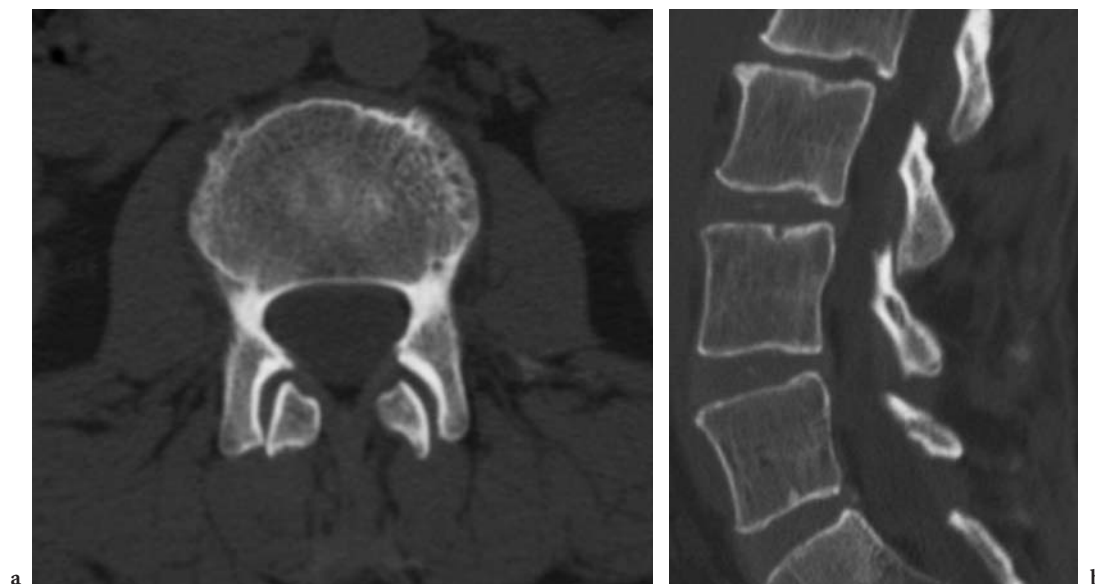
Facet joint subchondral bone changes. Axial CT image at the L4–L5 level shows degenerative changes of both facet joints, which is more pronounced at the left side. Hypertrophy and osteosclerosis, joint space narrowing, osteophytes and subarticular bone erosions (*white arrows*) are present
